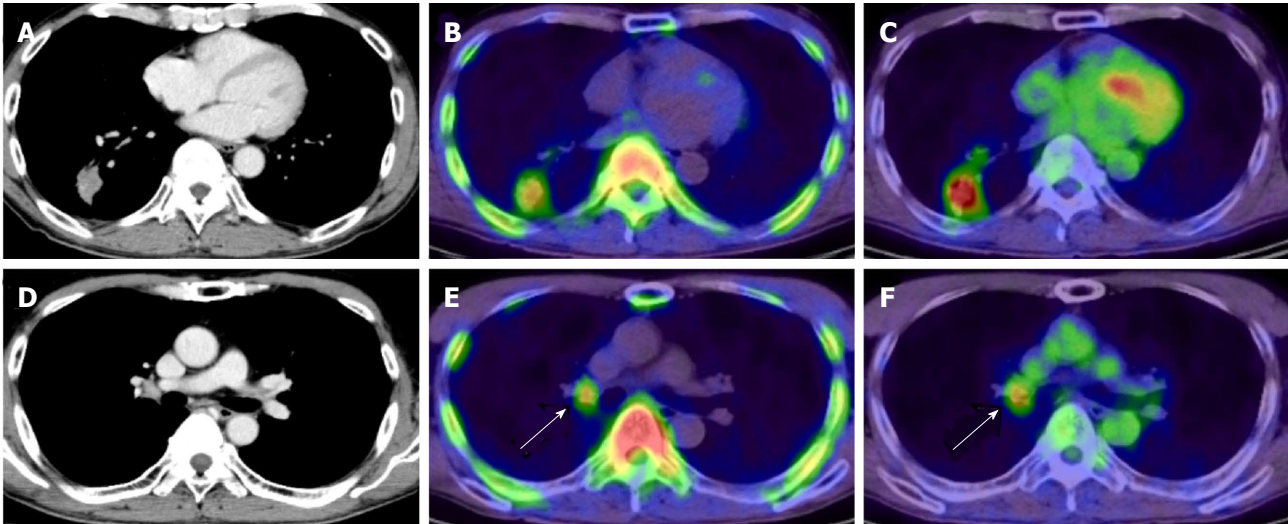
4'-[methyl- ^{11}C]-thiothymidine images in non-small cell lung cancer. Axial images of CT (A), ^{11}C -4DST PET (B), and ^{18}F -FDG PET (C) in a 58-year-old man with lung adenocarcinoma in the right lower lobe. Radioactivity of ^{11}C -4DST in the ascending aorta (representing blood pool) is lower than that of ^{18}F -FDG. Both ^{11}C -4DST and ^{18}F -FDG clearly visualize lung lesions. Right hilar lymph node metastasis is confirmed on CT (D), and uptake of both ^{11}C -4DST PET (E) and ^{18}F -FDG PET (F) identifies the lesion (arrow). However, ^{11}C -4DST images are clearer than ^{18}F -FDG images because of low physiologic ^{11}C -4DST in the mediastinum (blood pool). This research was originally published in JNM^[22]. ^{11}C -4DST: 4'-[methyl- ^{11}C]-thiothymidine; PET: Positron emission tomography; ^{18}F -FDG: 2-Deoxy-2-[^{18}F]fluoro-D-glucose; CT: Computed tomography.
